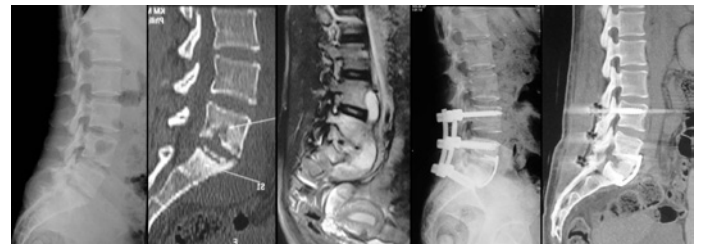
Fig Preoperative radiograph and MRI showed the osseous lesions and anterior abscess. At 24 months after operation, rigid bone fusion has been detected by CT scan.
